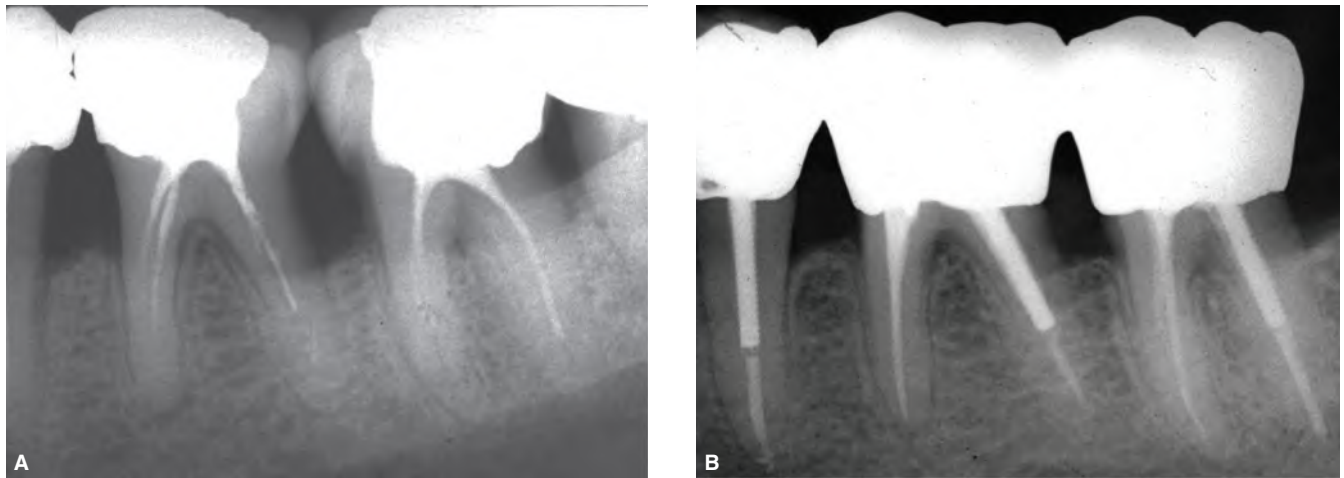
A. Retreatments are indicated in teeth with poorly sealed canals when a complex treatment planning involving periodontics and prosthodontics is scheduled. B. 12-year follow-up radiograph after retreatments and final restoration.
